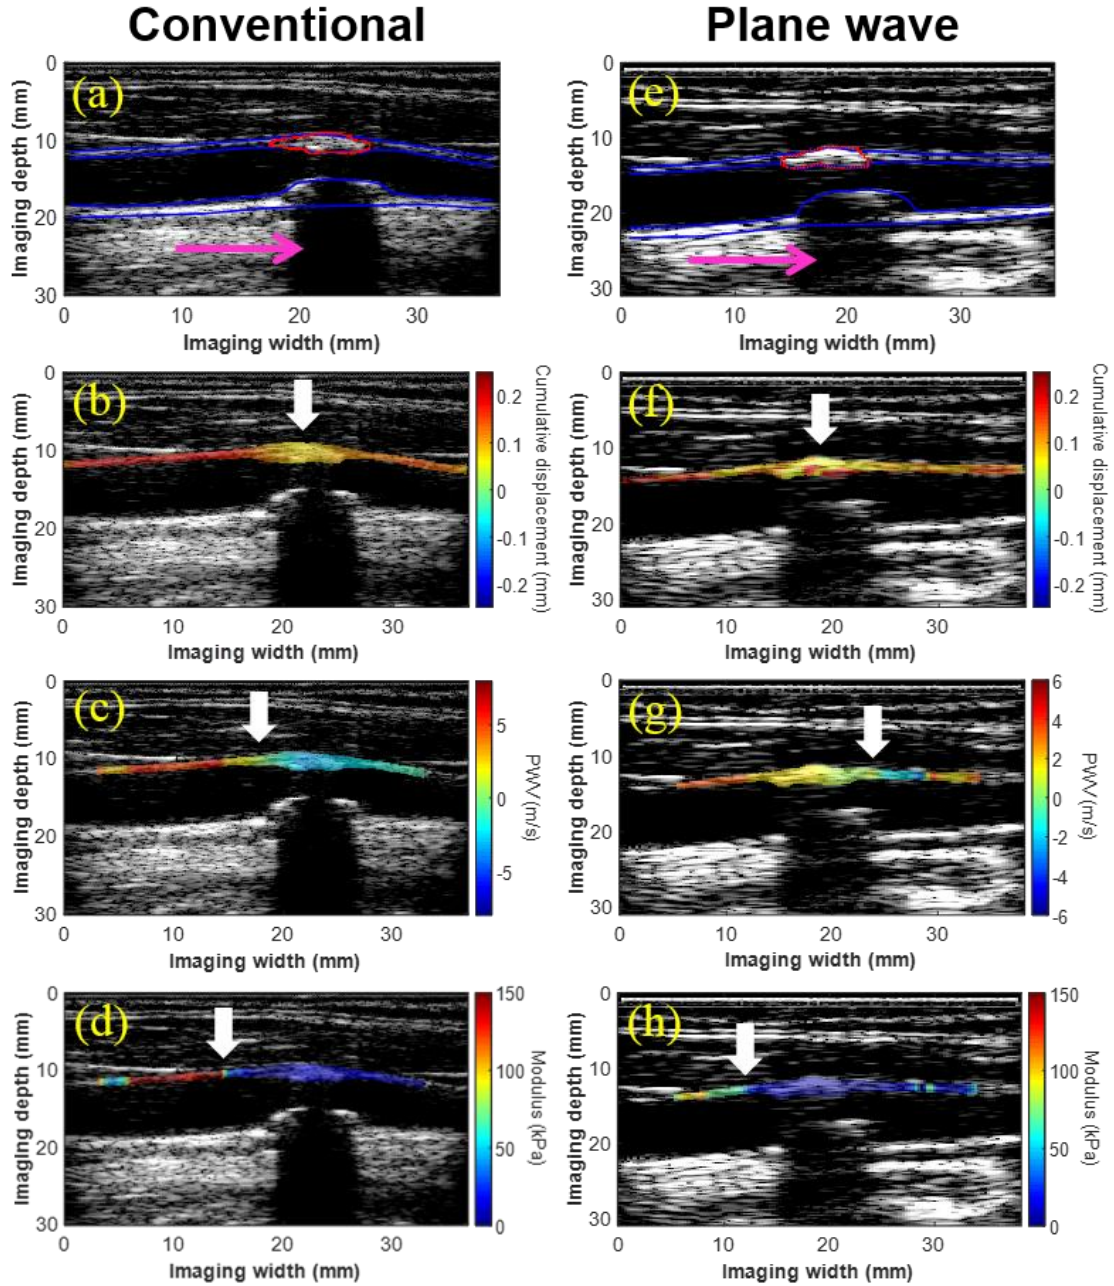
(a) B-mode image, (b) displacement map, (c) PWV map, and (d) modulus map from the right CCA of a 76-y.o. male obtained using a conventional ultrasound sequence. The pink arrow points to the acoustic shadow caused by the calcified posterior wall plaque, and the white arrows indicate regions of decreased displacement, pulse wave convergence, and a transition in modulus. The same location was scanned again during a 6-month follow up using a plane wave sequence (e-h), and similar results were observed.
